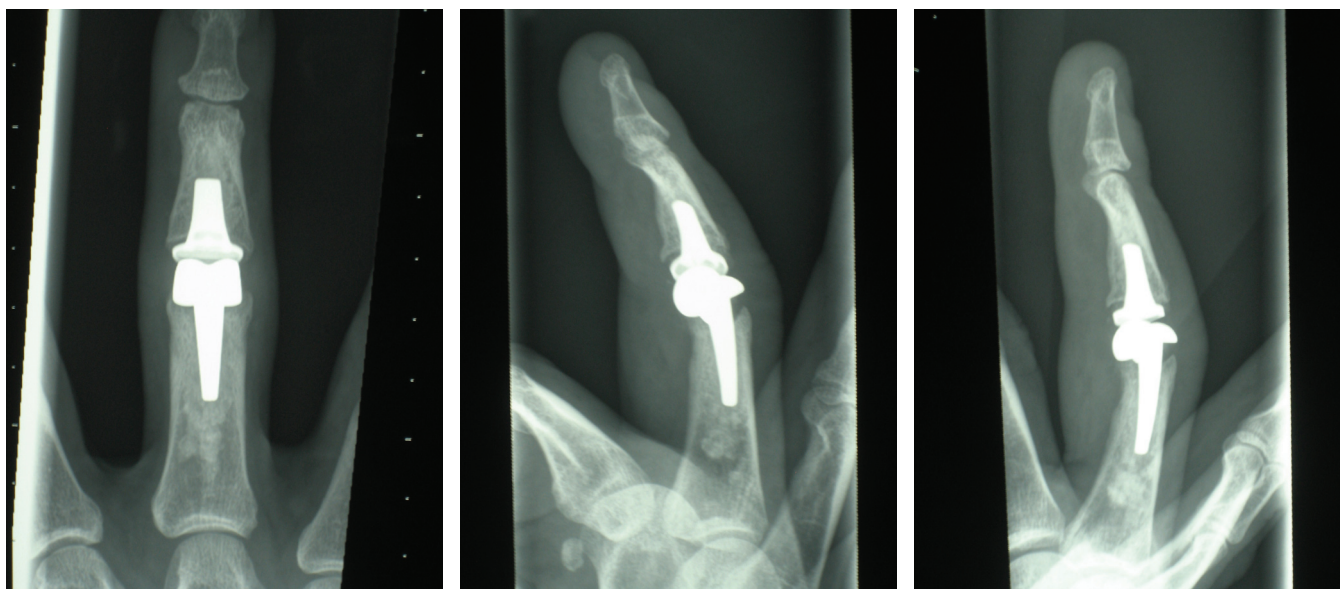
Radiographs of the same patient in Figure 1 taken 5.5 years after surgery. Note the slight subsidence of the proximal component and the radiolucency seen dorsally.
